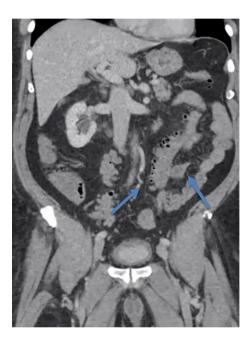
Computed tomography scan showing presence of numerous colonic diverticula (arrows).
